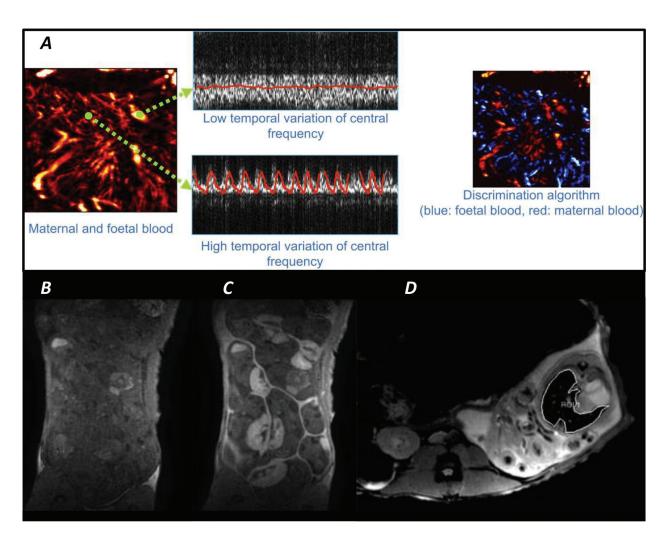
Placental blood flow mapping with discrimination of fetal and maternal circulation using ultrafast ultrasound Doppler in the rabbit model. With this technique, the pulsatility of each placental vessel is analyzed. Discrimination between maternal and fetal blood flows is performed using advanced analysis (A). Evaluation of placental blood flow with magnetic resonance imaging (MRI) in the rabbit model before (B) and after (C) injection of contrast product. Blood oxygen level-dependent MRI showing an axial view of the fetus with the fetal liver selected as the region of interest (D). (A–C are reprinted from ref. [66]; D is reprinted from ref. [71]).
